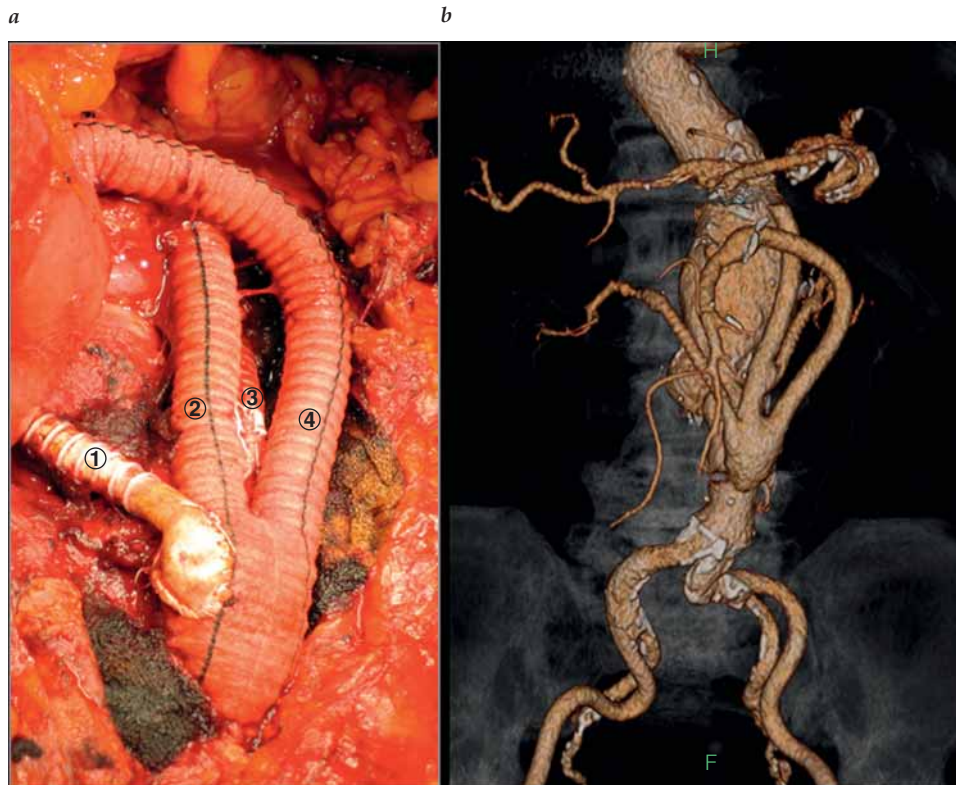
(a) Visceral artery bypass to 1, right renal artery; 2, celiac axis; 3, left renal artery; and 4, superior mesenteric artery. (b) Computed tomographic scan showing visceral bypass debranching prior to placement of an endograft.
